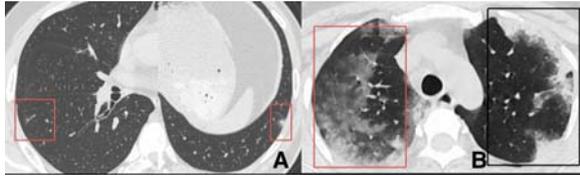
CT images of two different patients with COVID-19. First patient (A) had minor symptoms at presentation and only had subtle peripheral GGO on CT (red box). He did not require hospital admission and was conservatively managed. Second patient (B) had extensive GGO (red box) and consolidation (black box) at the time of presentation and required prolonged ICU care.
